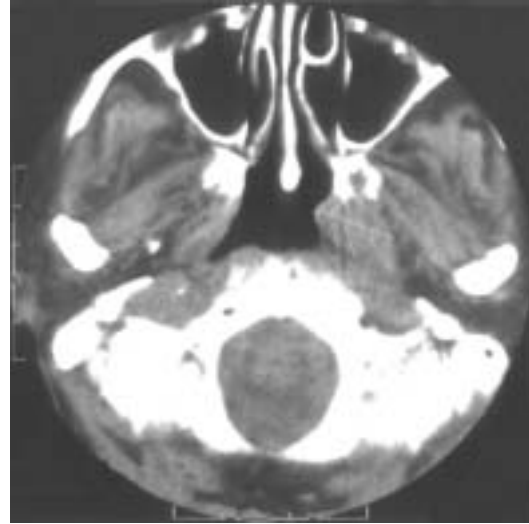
CT of epipharynx performed after the irradiation therapy shows the tumor mass with diameters 3.0 x 1.8 x 1.9 cm and an obvious tumor regression.
